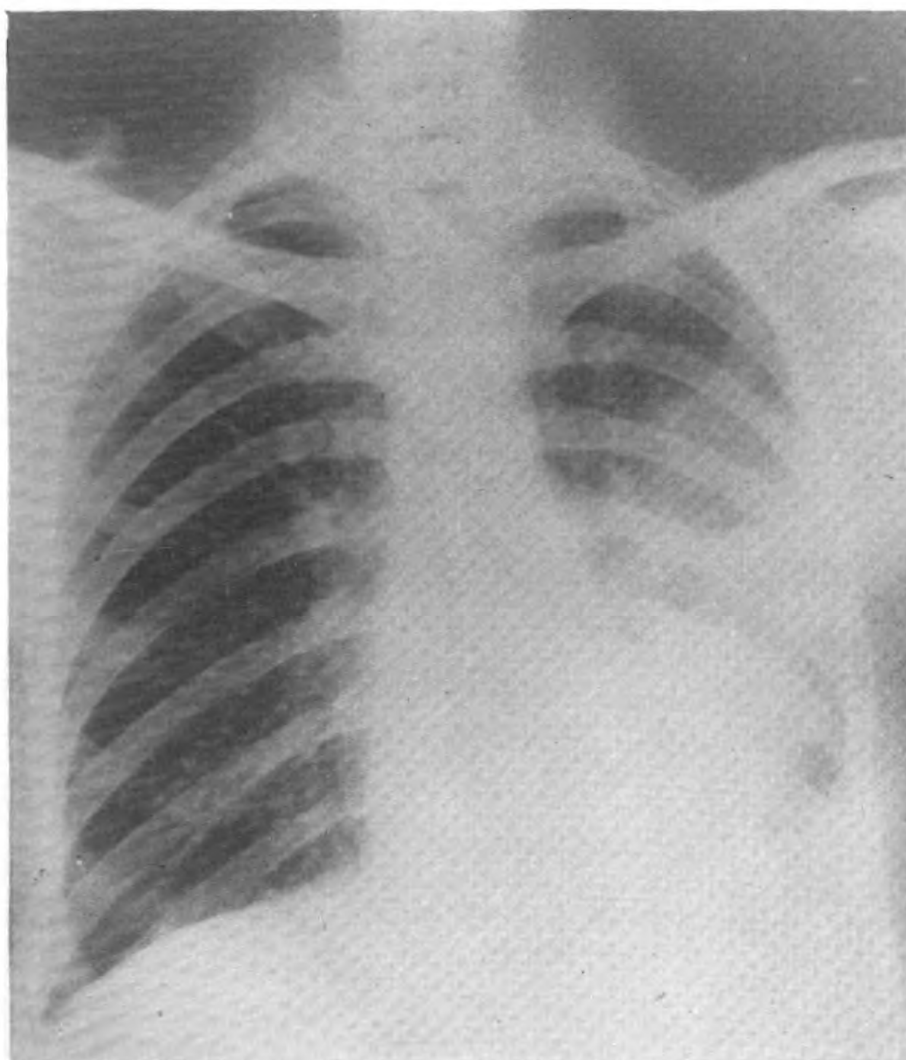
X-ray on 20 September 1945 showing soft infiltration of left middle and lower lung fields.*
